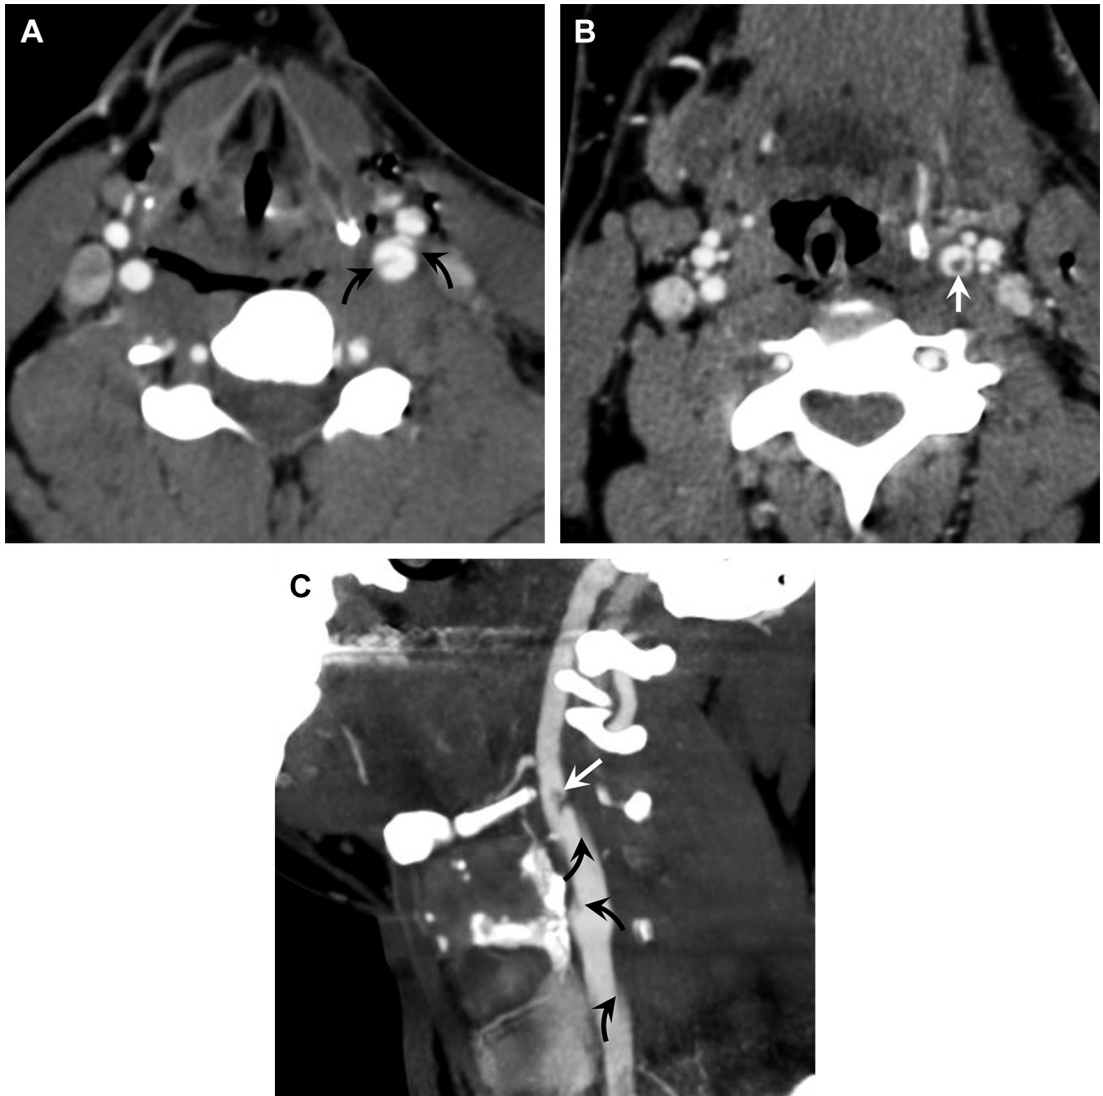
Traumatic dissection with intraluminal thrombus. Axial (A, B) and sagittal 2D reformatted (C) CTA images reveal a complex dissection of the proximal ICA (*black curved arrows*) with evidence of intraluminal thrombus (*arrow*), indicating a Denver grade 2 injury. This patient is at great risk for subsequent distal embolization unless treated with antithrombotic agents.
